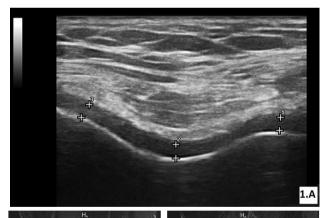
A. Ultrasound GS short axis image of the femoral hyaline cartilage, with the knee fully flexed. B, C. T2-weighed MRI images of the knee, with visible femoral cartilage and measurements of condyles (B) and intercondylar area (C).
